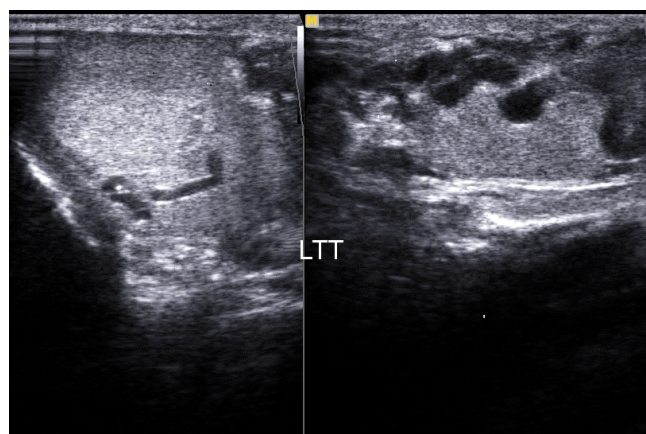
B-mode ultrasound demonstrating dilated serpiginous intratesticular tubular structures, predominantly in a subcapsular location, consistent with intratesticular varicoceles
